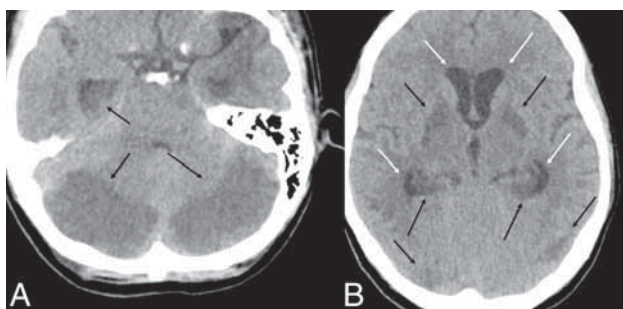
Representative findings on initial head CT. Axial NCCT demonstrates hypoattenuation within the cerebellar hemispheres and hypoattenuation within the posterior hippocampi (black arrows, A) and hypoattenuation within the basal ganglia, hippocampi, and cortex (black arrows, B). Developing hydrocephalus is present (white arrows, B).
